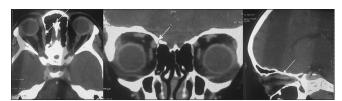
Axial, coronal and sagittal computed tomography scan sections showing enlargement of the right superior oblique muscle
